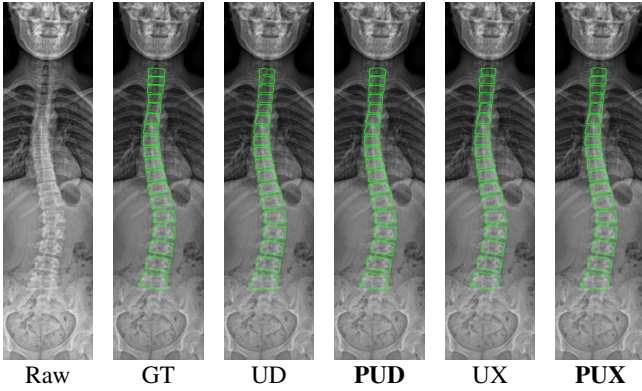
Boundary visualization of the predicted vertebrae masks in a spine X-Ray shows consistent improvement by our model over all other models.
